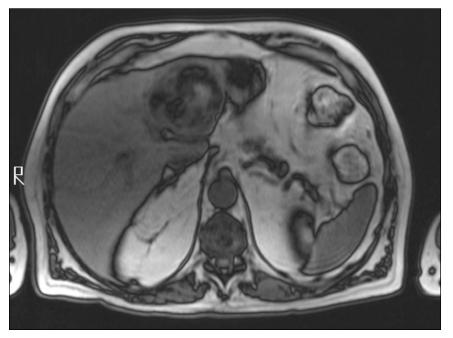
Chemical shift magnetic resonance image, showing a liver mass with fatcontaining hyperechoic areas.
